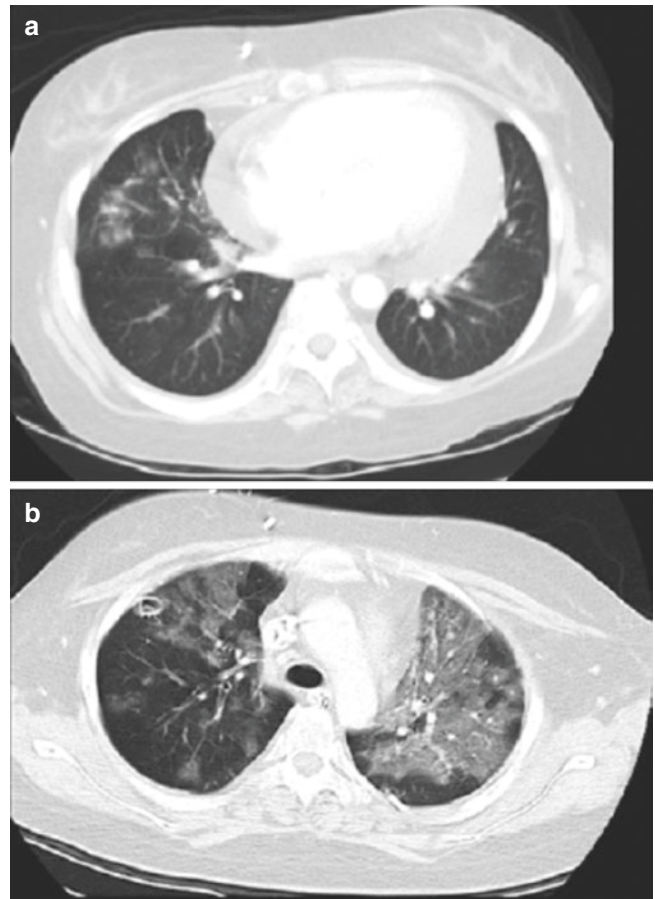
A 17-year-old girl with aplastic anemia status-post bone marrow transplantation 6 months prior to admission who presented with chest pain. (a) Axial lung window CT image obtained on day 1 shows ill-defined nodular pattern that was initially interpreted as fungal infection. (b) On day 9, this developed into a widespread ground-glass pattern with septal lines. Biopsy was suggestive of pulmonary veno-occlusive disease characterized by fibrous obstruction of a septal vein and preseptal venules with pulmonary hemorrhage
